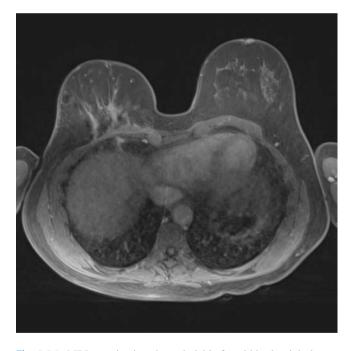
MRI examination showed viable fat within the right breast with some small oil cysts
